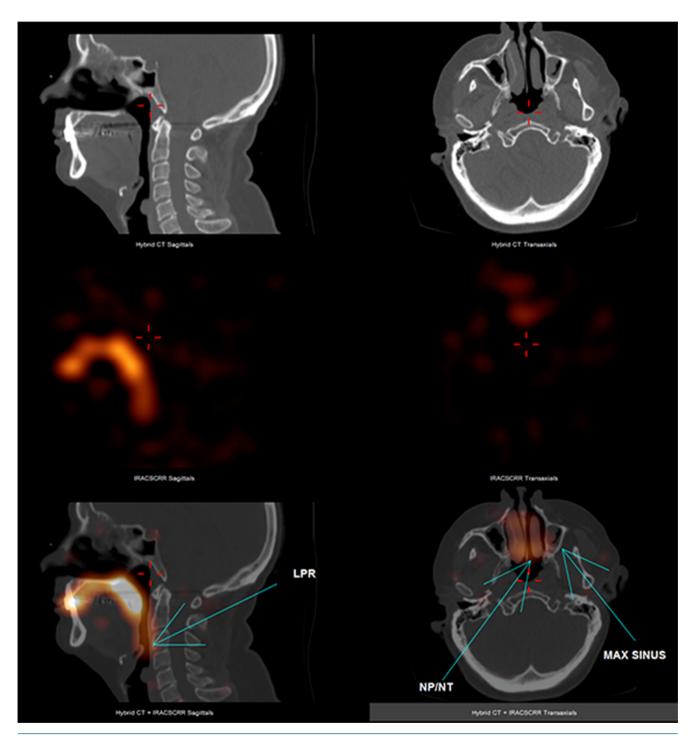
The low-dose SPECT/CT images of the head and neck in the sagittal and transaxial planes with fusion images show refluxate contaminating the laryngopharynx (LPR), nasopharynx (NP), nasal turbinates (NT) and the left maxillary sinus. Significant soft tissue thickening is apparent in the left maxillary sinus.
